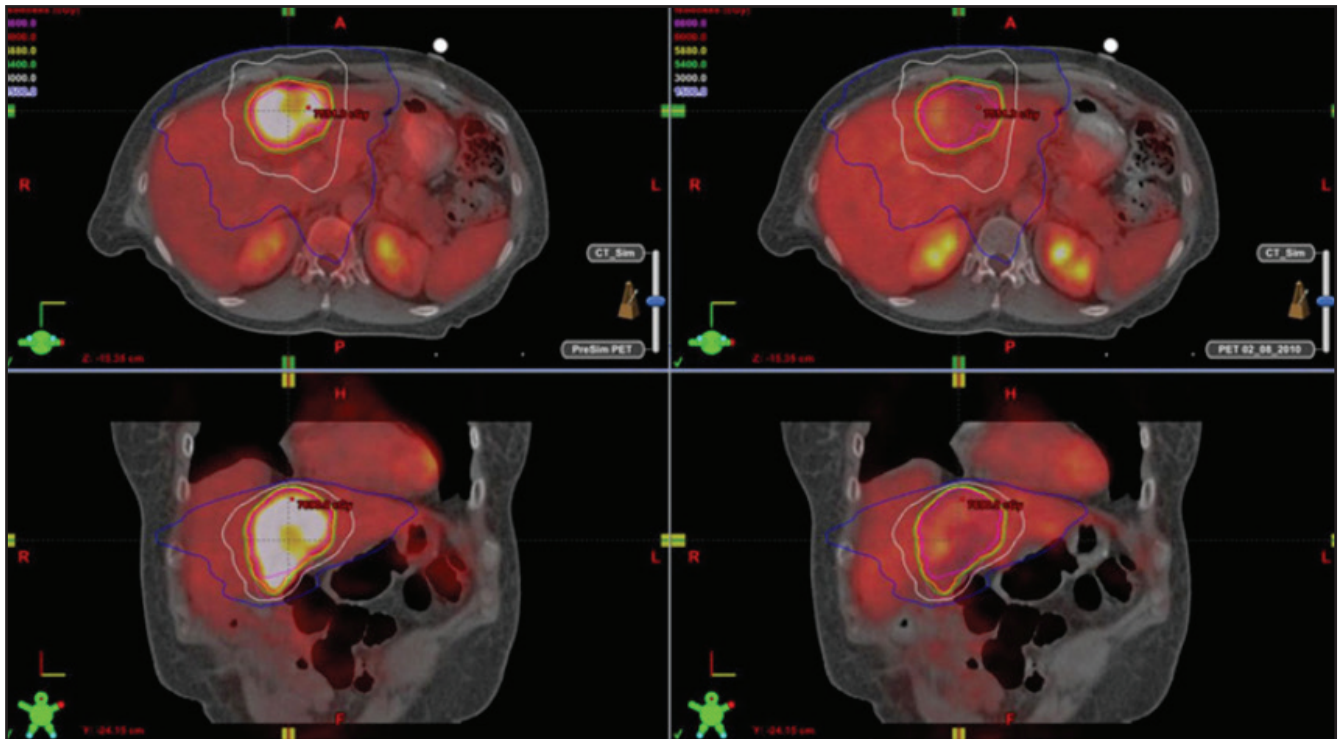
Pre (left) and post (right) SBRT treatment axial (top) and coronal (bottom) images of a large hepatocellular lesion treated on a Novalis Tx with RapidArc and HD120 MLC. The dose was 60 Gy over 5 sessions. The 30-day PET negative images on the right reveal no radiographic evidence of disease. This patient appears to have complete metabolic response after more than 2 years. Image courtesy of Percy Lee, MD, UCLA, Los Angeles, CA.
